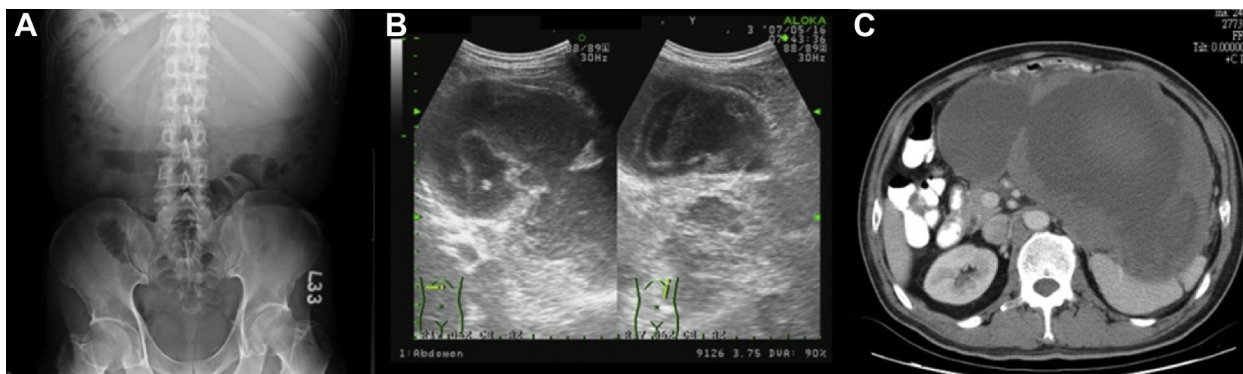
(A) Kidney, Ureter, Bladder (KUB) X ray found increased soft tissue density over the epigastric region with downward displacement of transverse colon gas; (B) sonographic finding of transverse and longitudinal view. There was a large cystic lesion with septation and mucous-like content in the epigastric and left upper quadrant of the abdomen. The pancreas was compressed downward by the tumor at the head and body; (C) computed tomography showed a large mass, approximately 23 cm × 13 cm × 20 cm, with low density at the central region and peripheral enhancement. The spleen and stomach were heavily compressed by the tumor mass.
